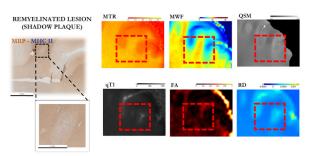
A): Quantitative MRI (qMRI) measures applied to assess the presence of WM remyelinated lesions in postmortem blocks (Galbusera R.et al., Brain Path 2023); B) qMRI measures applied to assess focal remyelination in cortical lesions (Galbusera R. et al., ECTRIMS 2023)
